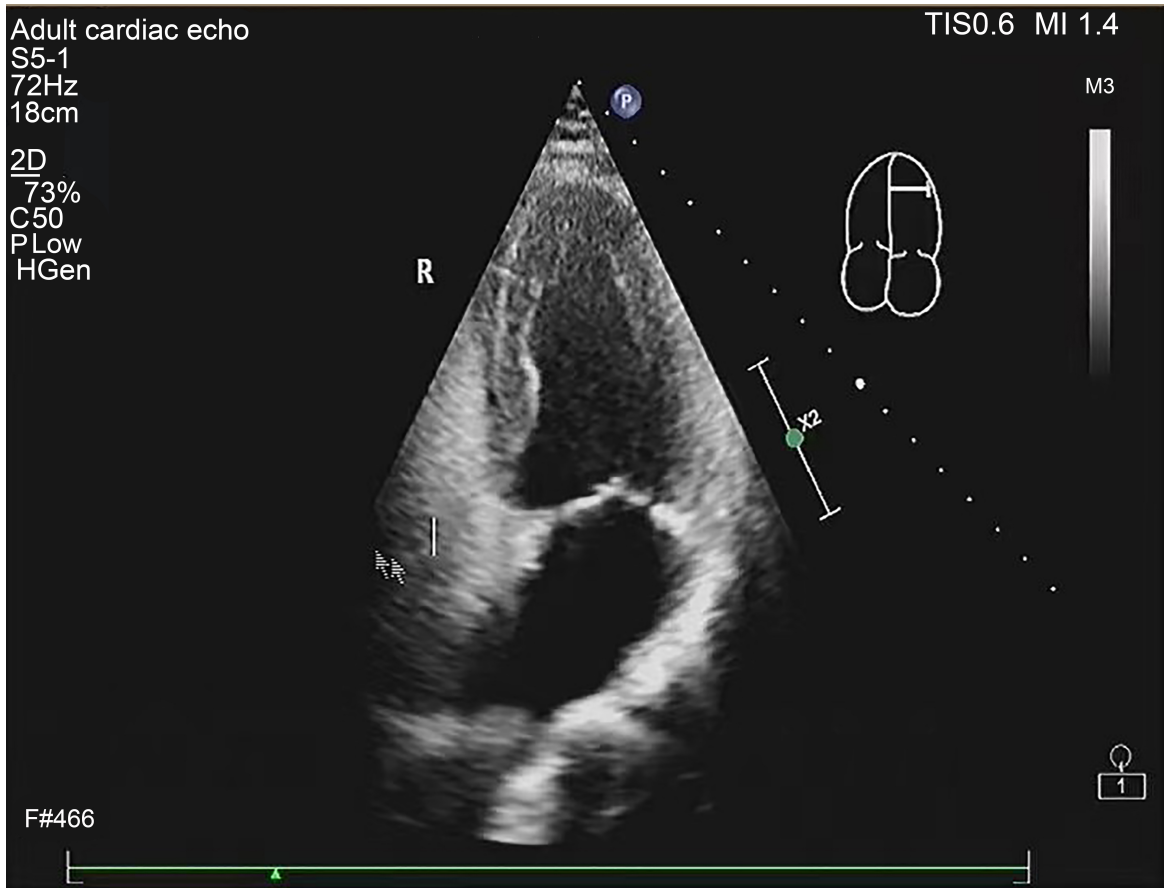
Right heart contrast echocardiography at rest.
